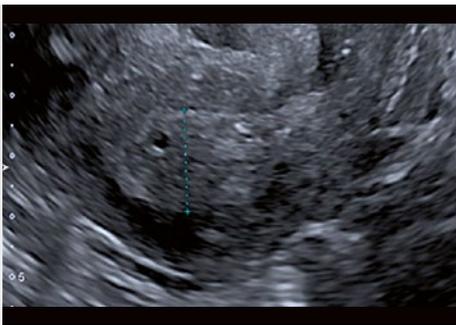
Endometrial thickness measurement using transvaginal ultrasound.
